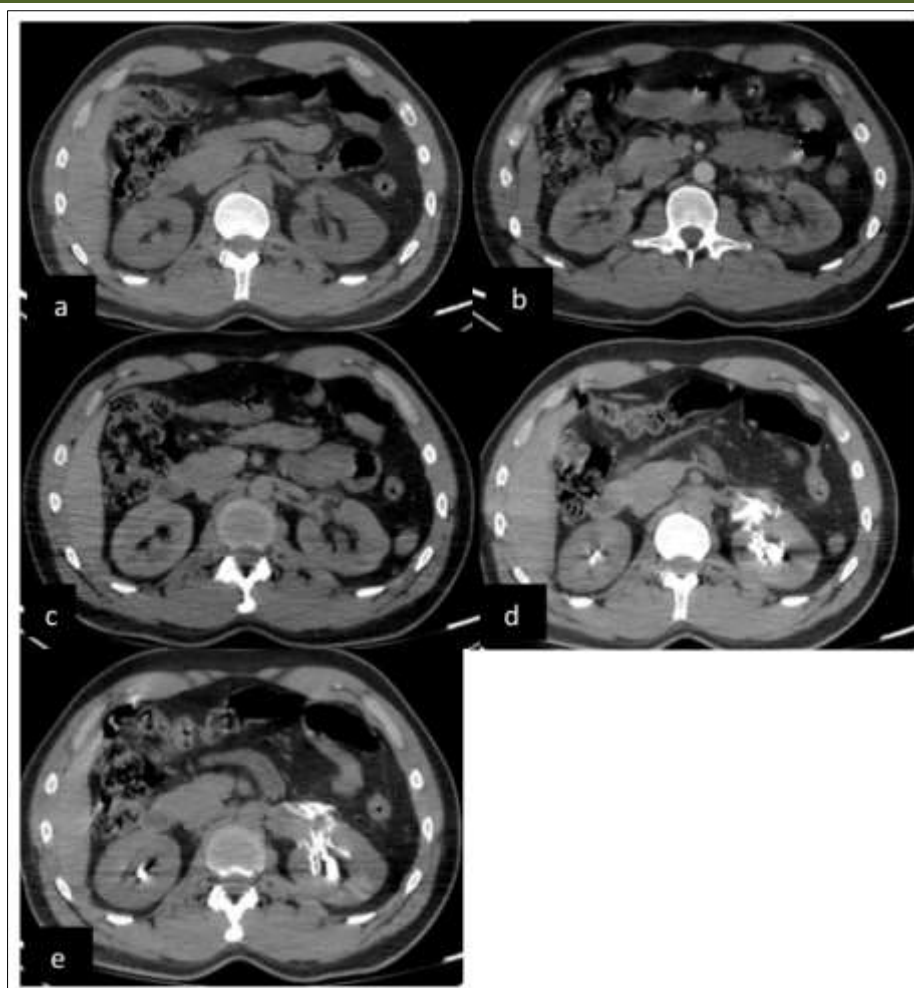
Axial CT-urography images without contrast (a), following contrast at arterial phase (b), portal venous phase (c), and delayed phase (d and e)
